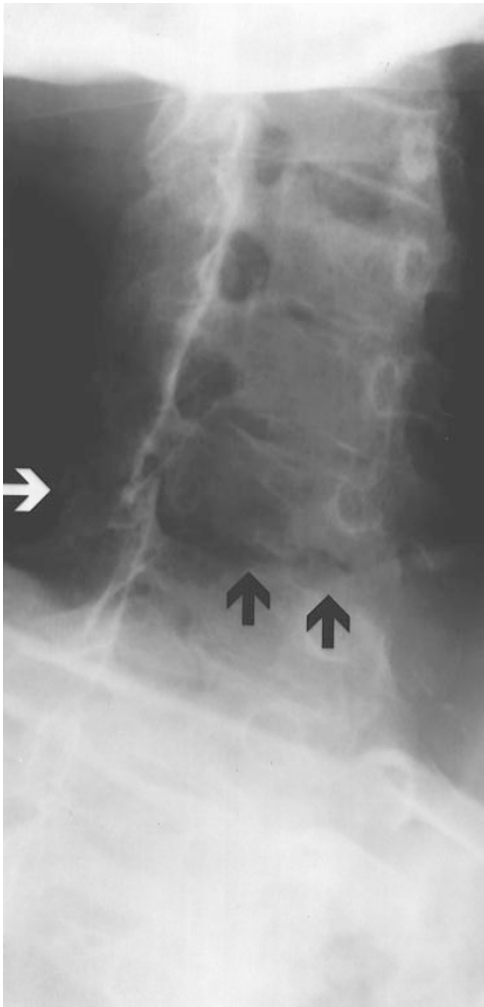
Right anterior oblique radiograph of the cervical spine shows a transverse fracture of the C6-C7 disc (black arrows) extending to the ankylosed posterior facets (white arrow)
